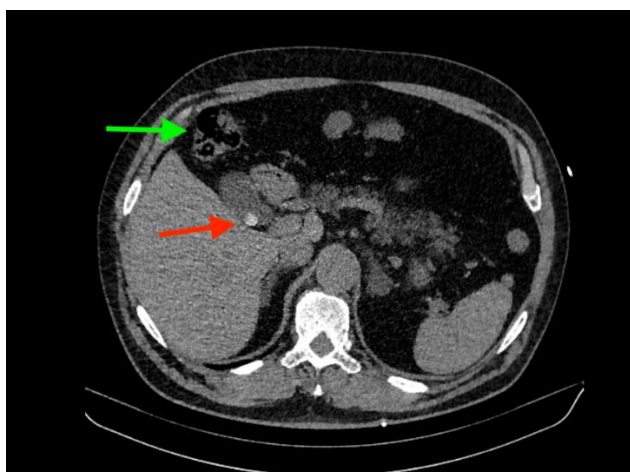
Coronal computed tomography image on admission, demonstrating a mildly thickened hepatic flexure [green arrow] with an incidental gallstone [red arrow] and no signs of cholecystitis or intra-hepatic abscesses
